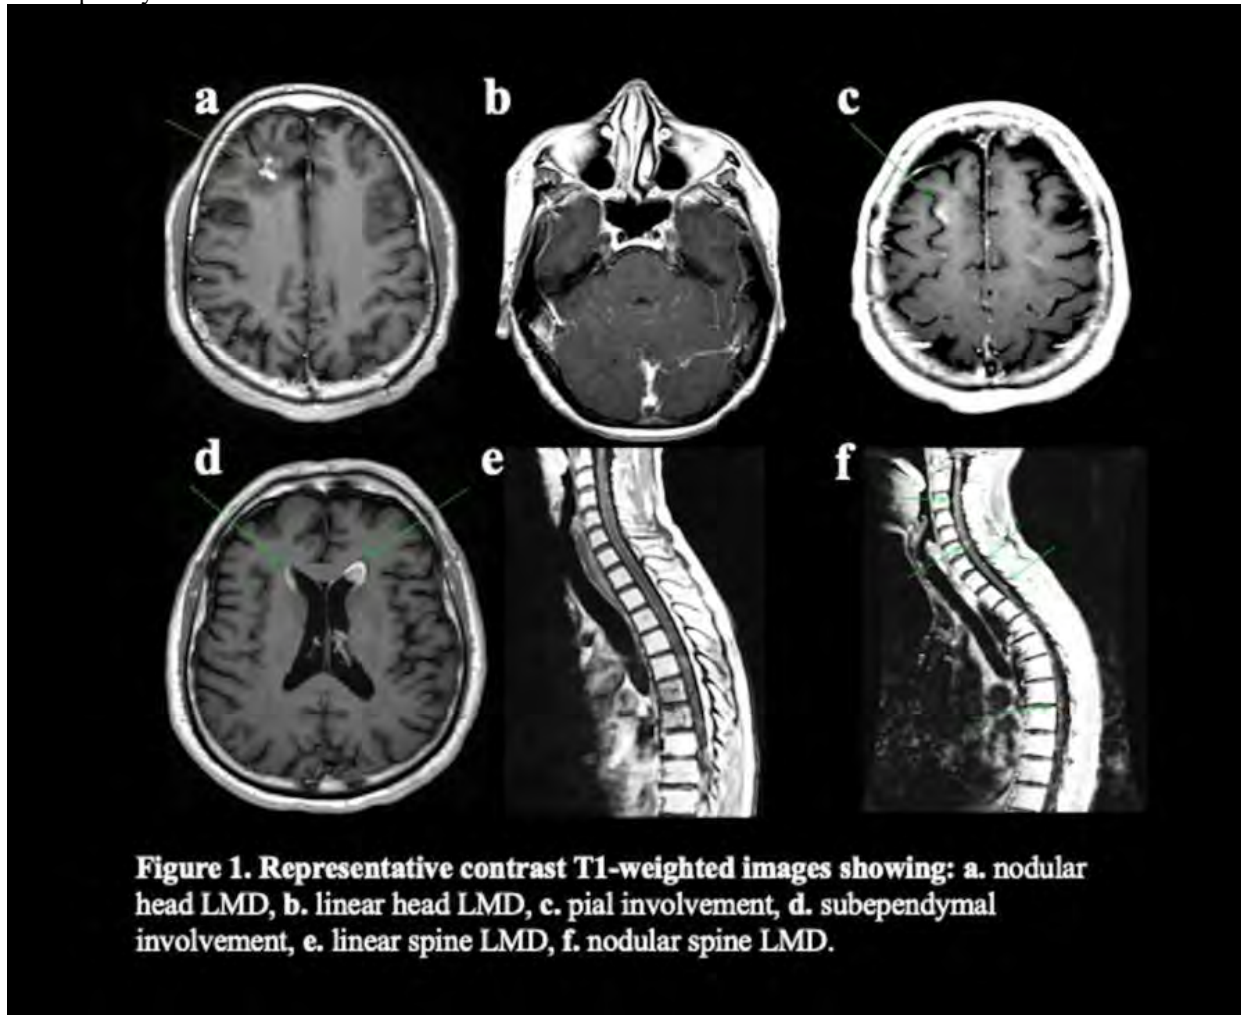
Representative contrast T1-weighted images showing: a. nodular head LMD, b. linear head LMD, c. pial involvement, d. subependymal involvement, e. linear spine LMD, f. nodular spine LMD.
